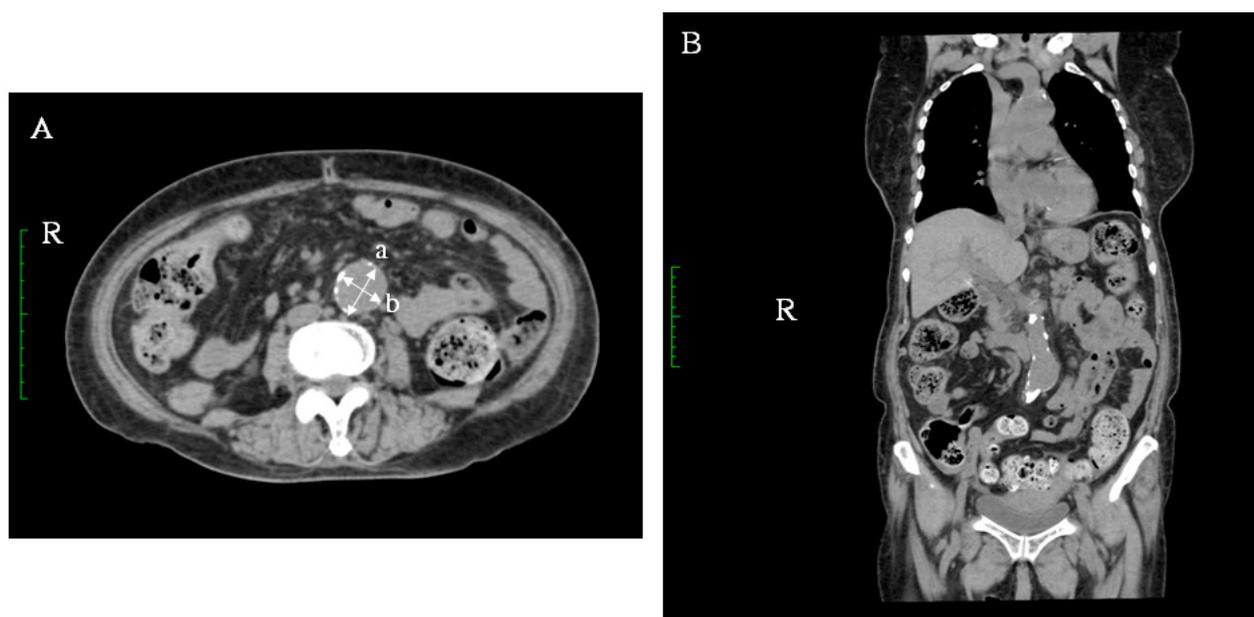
Coronal (A) and axial (B) plain CT images at the abdominal level in Case 3.
